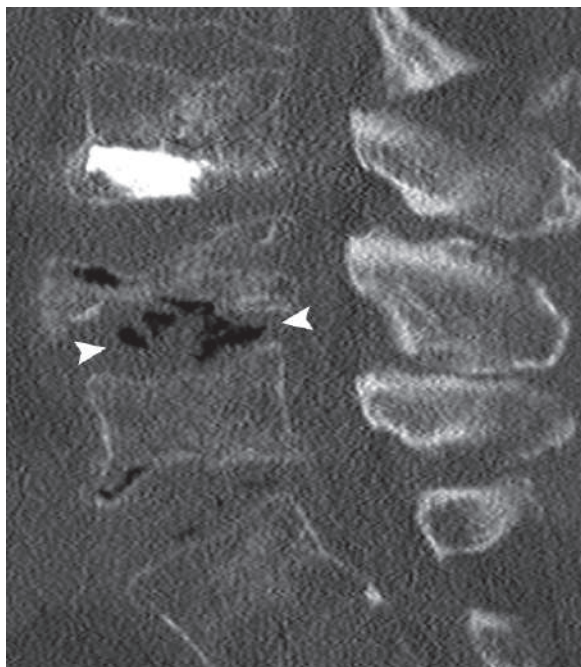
Sagittal lumbar CT image in a patient with osteoporosis shows severe osteopenia, collapse of L4 vertebra (*vertebra plana*), vertebroplasty of L3, with gas formation located in the intervertebral disc space between L4 and L5 (*arrows*)
